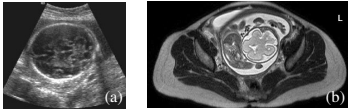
(a) and (b) are a typical ultra-sound fetal image and a MR T2-W image. MRI can achieve much more anatomic details.
